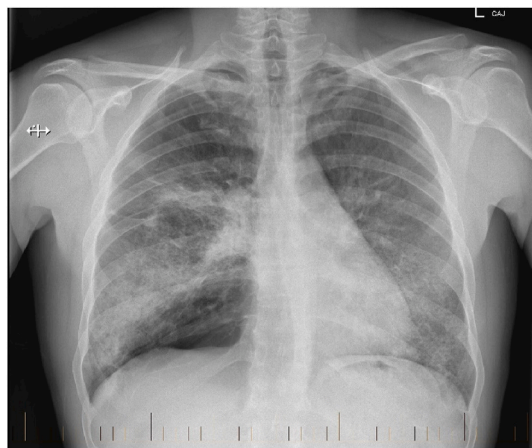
Baseline Chest X-ray at time of presentation shows diffuse alveolar opacities in the bilateral mid and lower zones, along with bullous disease in the right base and apex consistent with a number of differentials.
